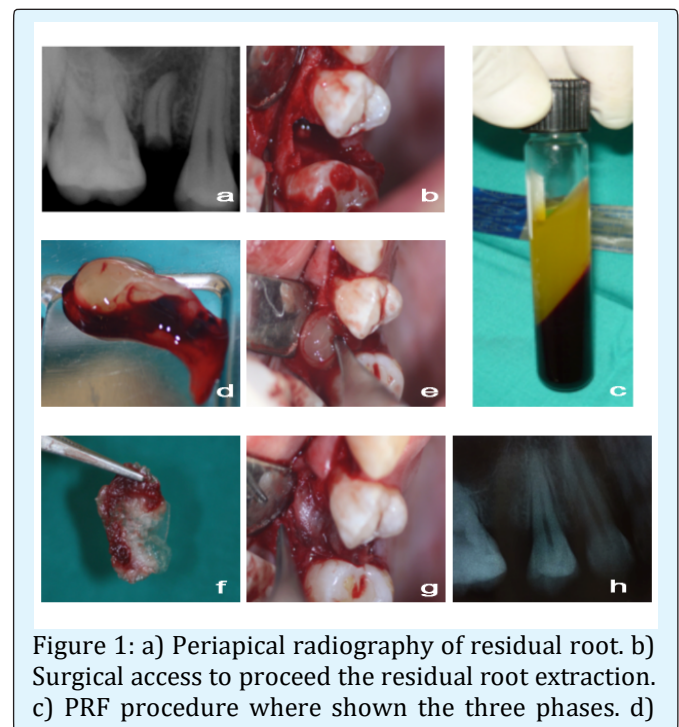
a) Periapical radiography of residual root. b) Surgical access to proceed the residual root extraction. c) PRF procedure where shown the three phases. d)
